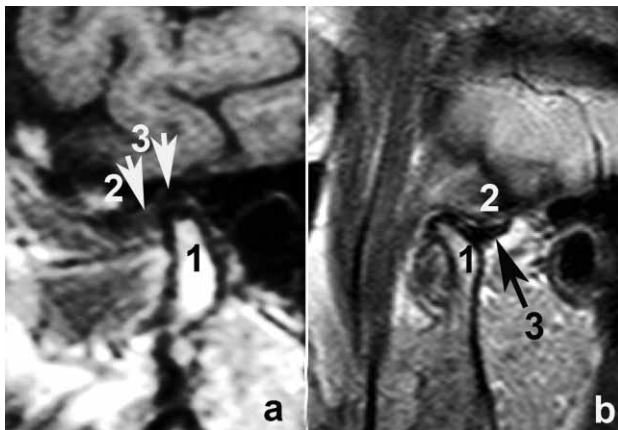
MRI showing right TMJ with disc in physiological position (a, closed mouth). In the open mouth position (b) condyle is extremely anterior and hypermobile and disc is more posteriorly positioned on the articular eminence than the condyle (1, condyle; 2, articular eminence; 3, disc).
